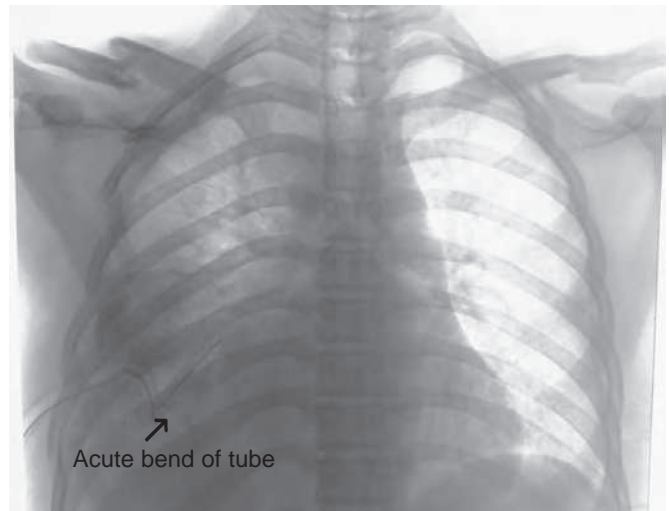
Chest radiograph showing acute kink of the chest drain tube causing reaccumulation of blood in the right thoracic cavity
